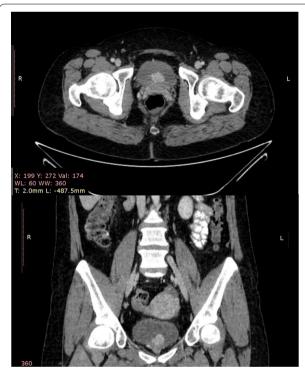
CT scan showing an intraluminal bladder mass
